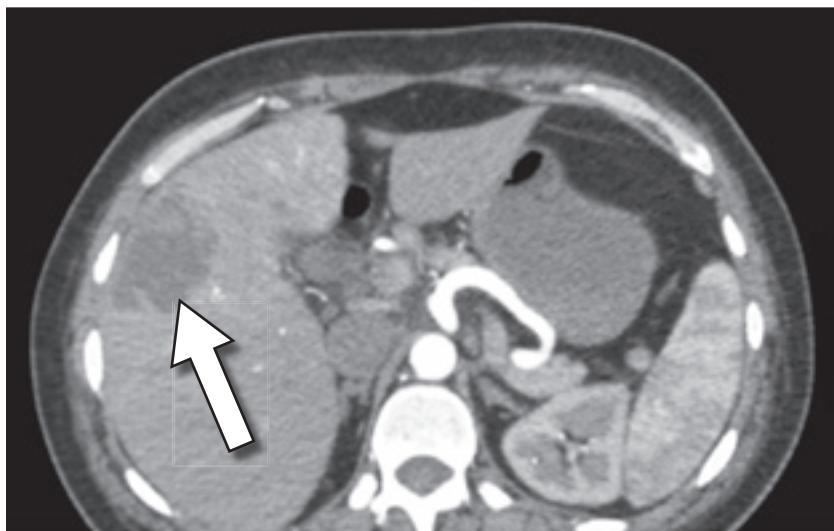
CT scan of abdomen showing large multiloculated mass in anterior right lobe of the liver (arrow).
